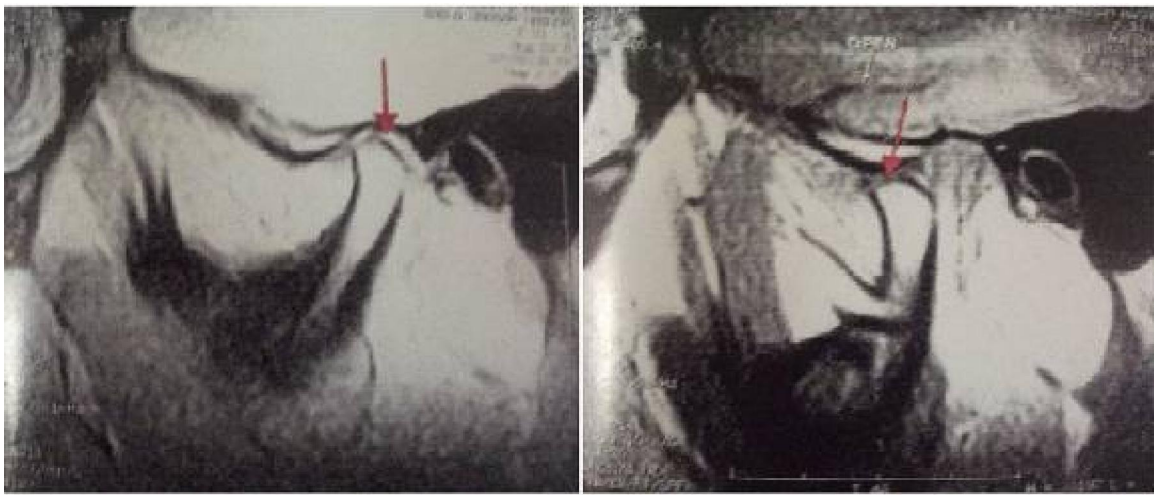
Sagittal MR image (TR= 500msec; TE=11msec) of the left TMJ showing normal disc relation (left; closed mouth. Right; opened mouth)
